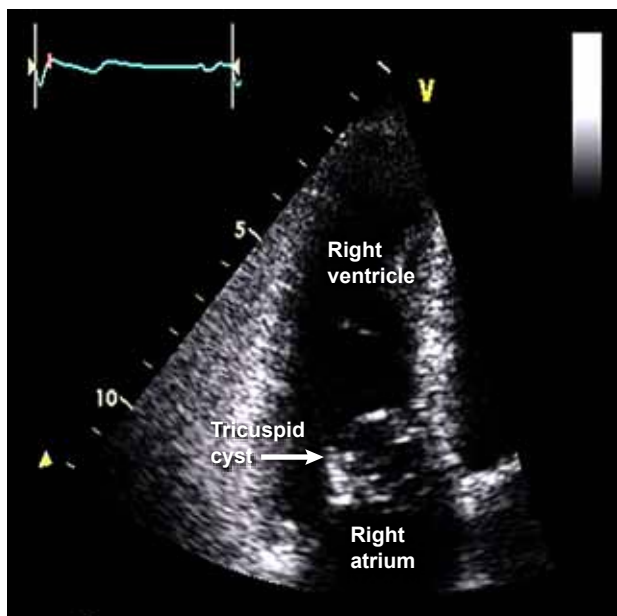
Transthoracic two-dimensional echocardiogram, showing the cyst attached to the septal tricuspid leaflet.
